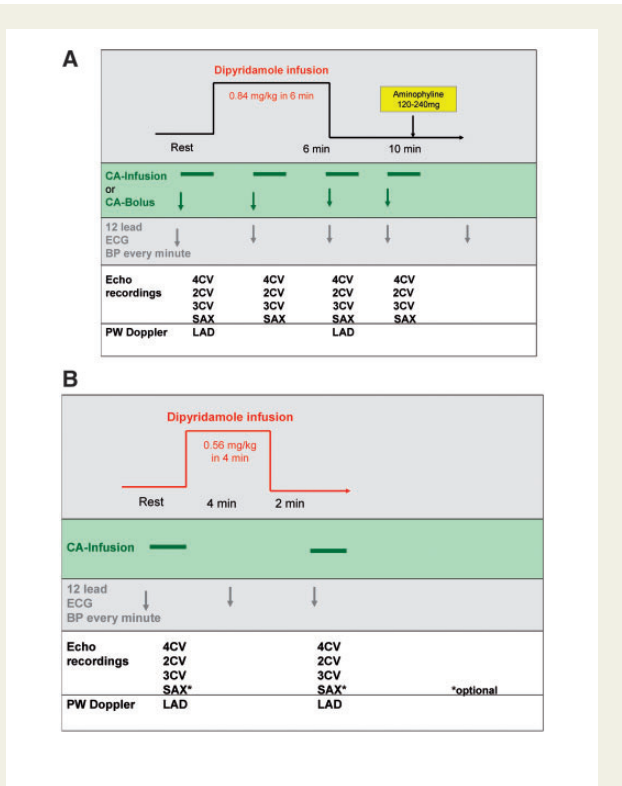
Protocol of state-of-the-art high-dose dipyridamole SE suggested by the EAE²¹⁵. In addition to 2D echocardiographic recordings measurement of the blood flow in the LAD is recommended at rest and at the end of the dipyridamole infusion. (B) Protocol for low-dose dipyridamole SE, which is suitable assessment of myocardial perfusion.
